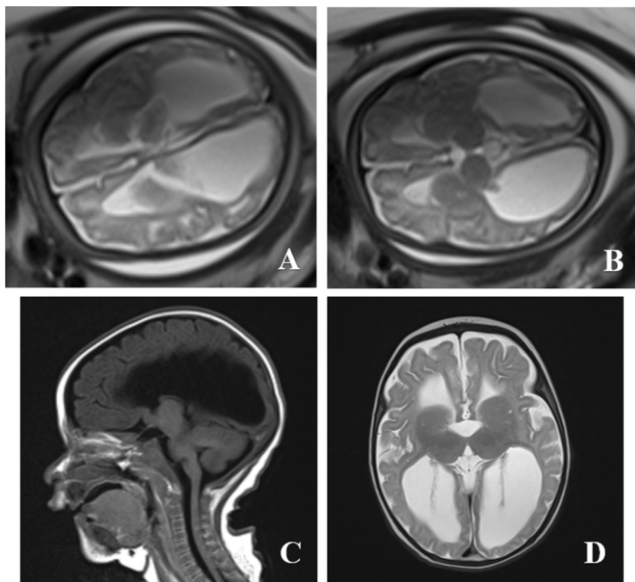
CORPUS CALLOSUM AGENESIS: Axial T2WI (A and B) of the fetal head at 40 weeks' gestation absence of interconnecting fibres of corpus callosum between cerebral hemispheres and colpocephaly. Postnatal MRI with sagittal T1WI (C) and axial T2WI (D) confirms the prenatal diagnosis of corpus callosum agenesis with colpocephaly.
